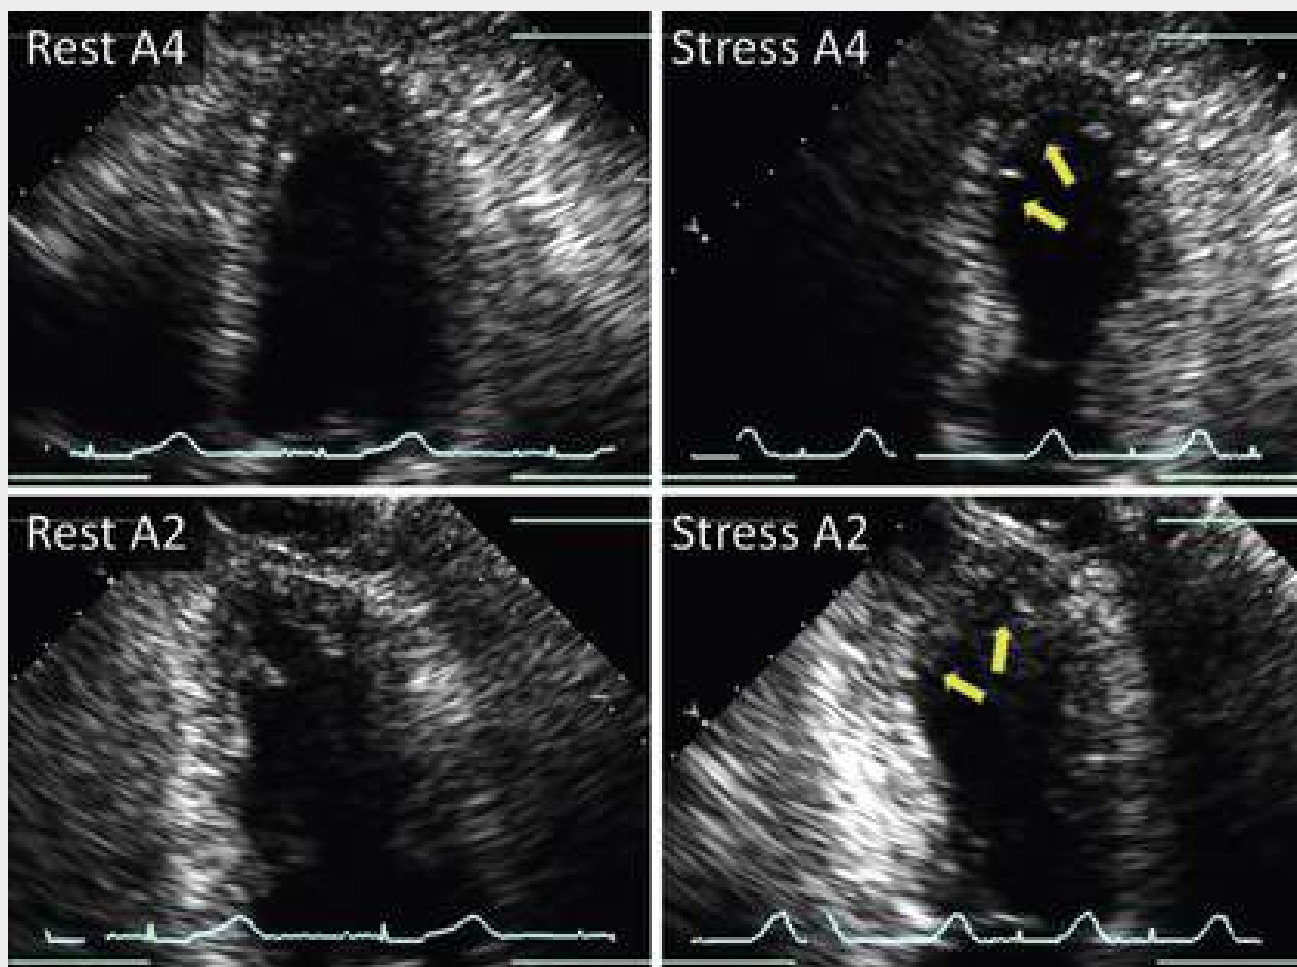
Stress echocardiography showing evidence of ischemia in the left anterior descending (LAD) distribution. Resting and stress echocardiograms in the apical four-chamber (A4) and apical two-chamber (A2) views reveal new severe middle to distal septal, apical, and distal inferior LV hypokinesis (arrows). This patient was found to have greater than 90% mid-LAD stenosis on cardiac catheterization. (See Video 14.24.)
